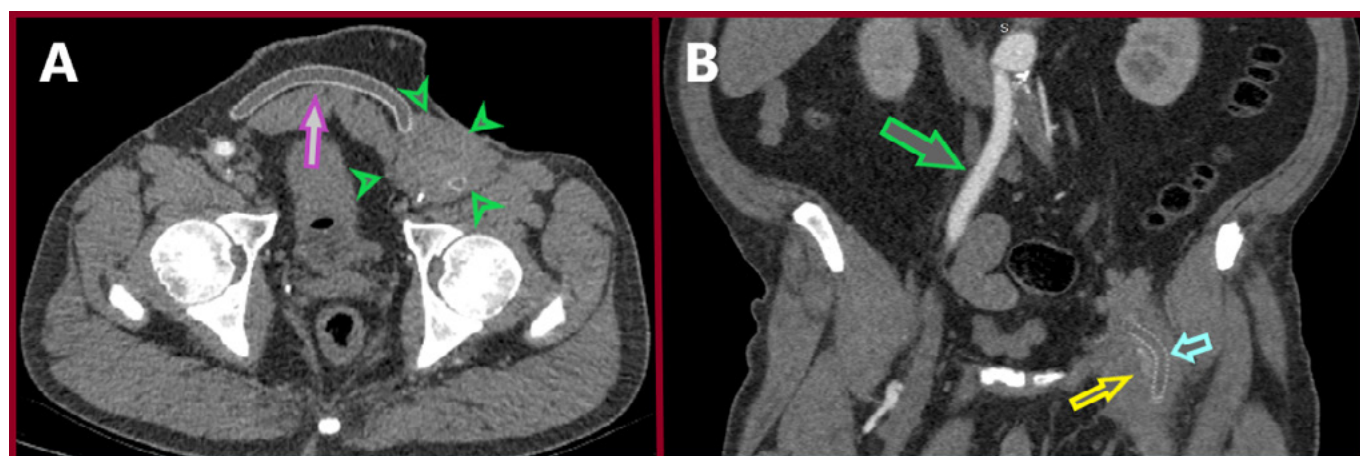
A computed tomography angiography revealed an aortofemoral left limb and femorofemoral bypass thrombosis and a patent right limb of an aortobifemoral bypass. A blood pooling was apparent in the left groin, arising from the orifices of the profunda femoral artery. Signs of Leriche syndrome are apparent in the aortoiliac system (A: green arrowheads: anastomotic pseudoaneurysm with a bleeding sinus, purple arrow: thrombosed femorofemoral bypass. B: green arrow: blood pooling due to anastomotic hemorrhage).
